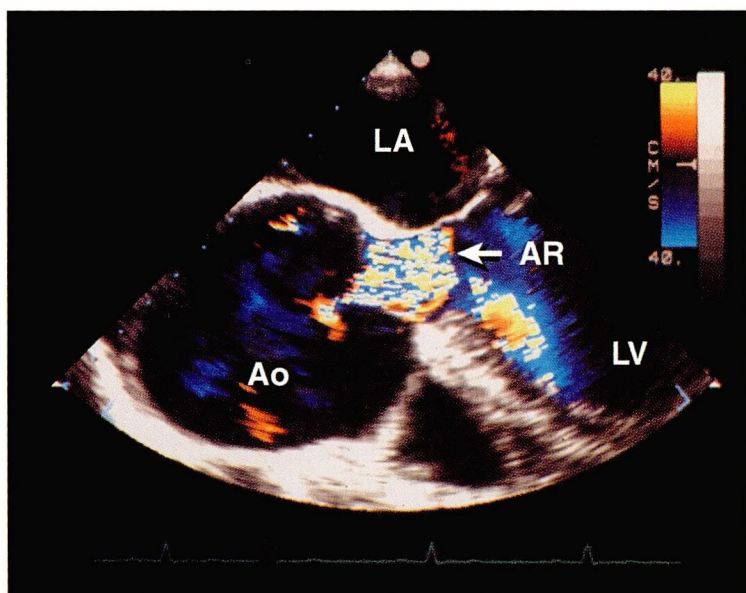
A Doppler transesophageal echocardiogram of an adult male with Marfan syndrome. Note the dilatated aorta (Ao) and the resultant aortic regurgitation (AR). LA, left atrium; LV, left ventricle.
